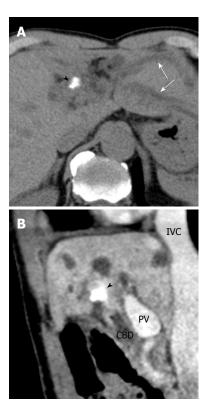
Findings of computed tomography. A: Plain transverse computed tomography (CT) reveals a high-density area at the liver hilus (arrow head) with dilated left intrahepatic bile ducts (arrows); B: Sagittal plane of enhanced CT shows the perihilar high-density area (arrow head). PV: Portal vein; IVC: Inferior vena cava; CBD: Common bile duct.
